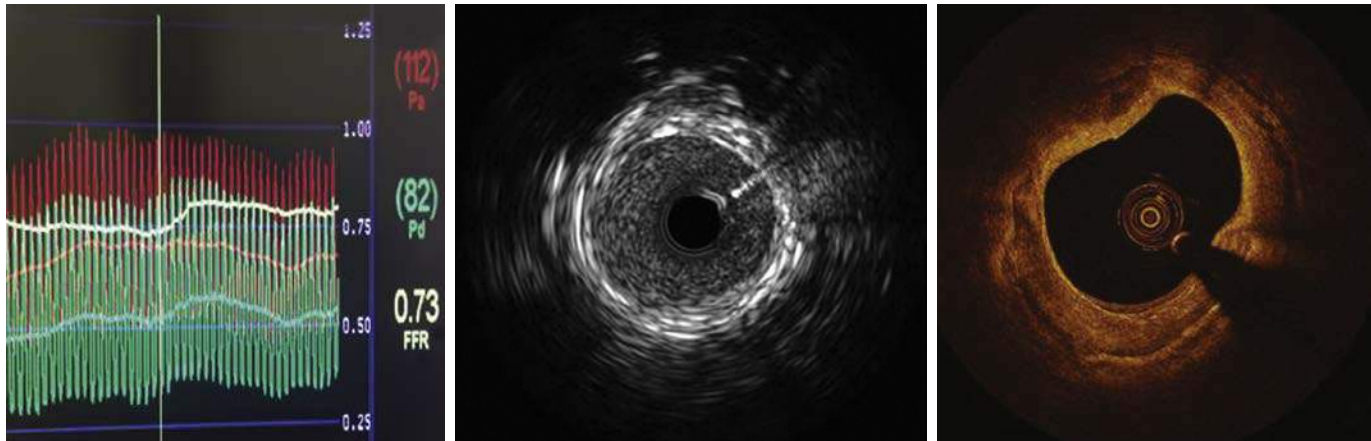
Left, Fractional flow reserve displaying ratio of pressures across an arterial stenosis as assessment of physiologic significance. Middle, Intravascular ultrasonography cross-sectional display of a previously stented segmental pulmonary artery. Right, Optical coherence tomography cross-section of a coronary artery.
